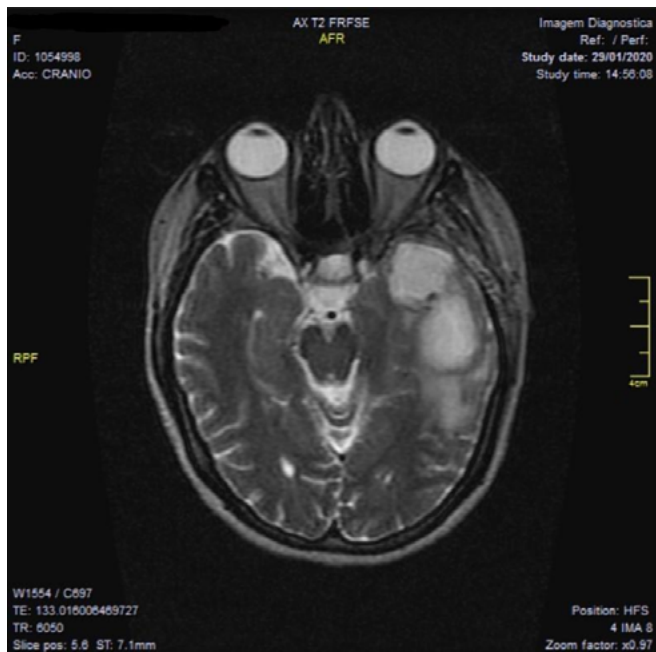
Contrast-enhanced cranial magnetic resonance imaging, axial, T2, performed on January 29, 2020.
